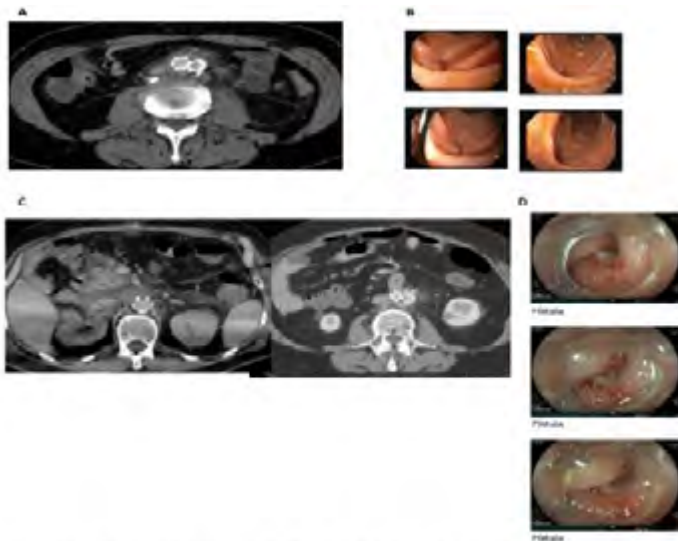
A- Abdominopelvic CTA at 6 months after EVAR which shows diffuse denaturation of fat around the abdominal aorta, without organized fluid collections capable of drainage. B- Endoscopy revealing aorto-enteric fistula at D9-D10 transition. C- Abdominopelvic CTA at 2 years and 5 months after EVAR which showed an aortic bi iliac endoprosthesis permeable but with a diffuse denaturation of fat around the abdominal aorta, without organized fluid collections capable of drainage and presence of periaortic gas. D- Endoscopy revealed an aorto-enteric fistula with exposure of aortic graft material.
